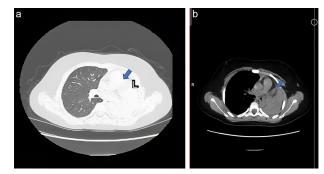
(a) Chest CT revealed an ill-defined hypodense, heterogeneously enhancing soft tissue mass in the left main bronchus. (b) Mediastinal window Chest CT revealed an ill-defined hypodense, heterogeneously enhancing soft tissue mass in the left main bronchus.
